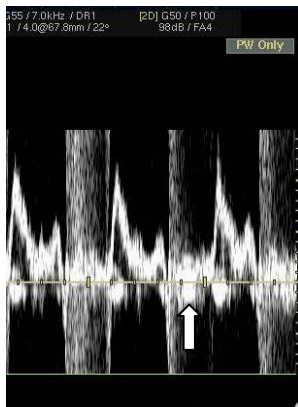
Pulse wave Doppler echocardiography from position heart apex. Transmittal the blood stream is partially directed below a base line of the spectrogram that is a sign of mitral regurgitation (arrow). Mitral regurgitation
